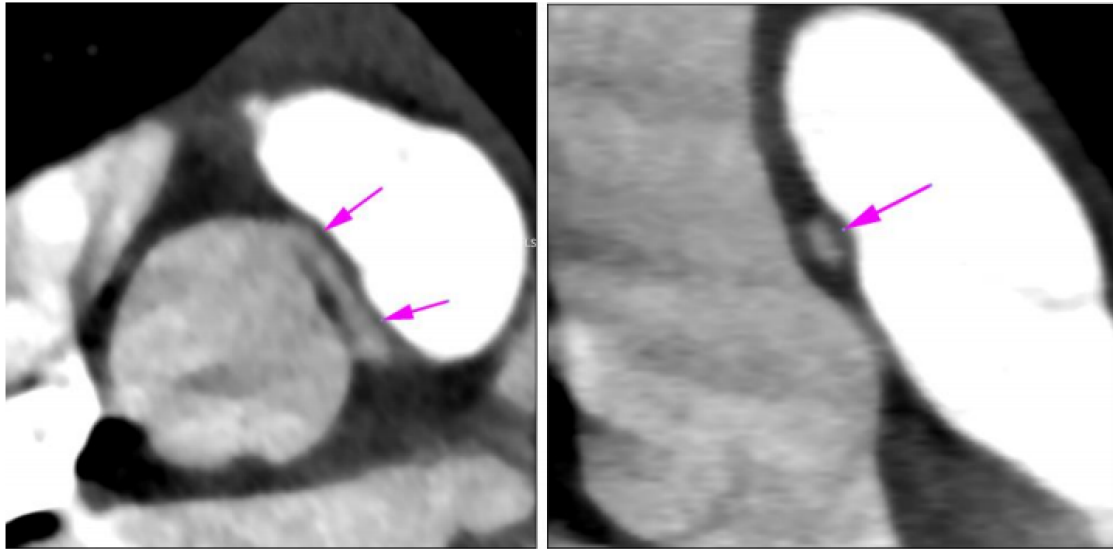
Cardiac computed tomographic angiography showing the malignant path of the left coronary artery.
